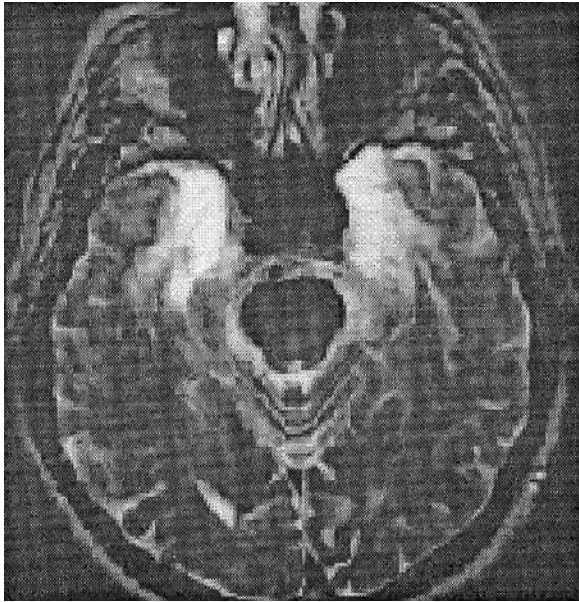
T_2 -weighted MRI image showing an axial slice through the temporal lobes of patient E.P. Damage to the bilateral medial temporal lobe extends caudally from the temporal pole and includes the hippocampal region, the entorhinal cortex, the perirhinal cortex, the parahippocampal cortex and the amygdaloid complex. The lesion also extends laterally to include the anterior portion of the fusiform gyrus. (Adapted from Teng & Squire, 1999.)
